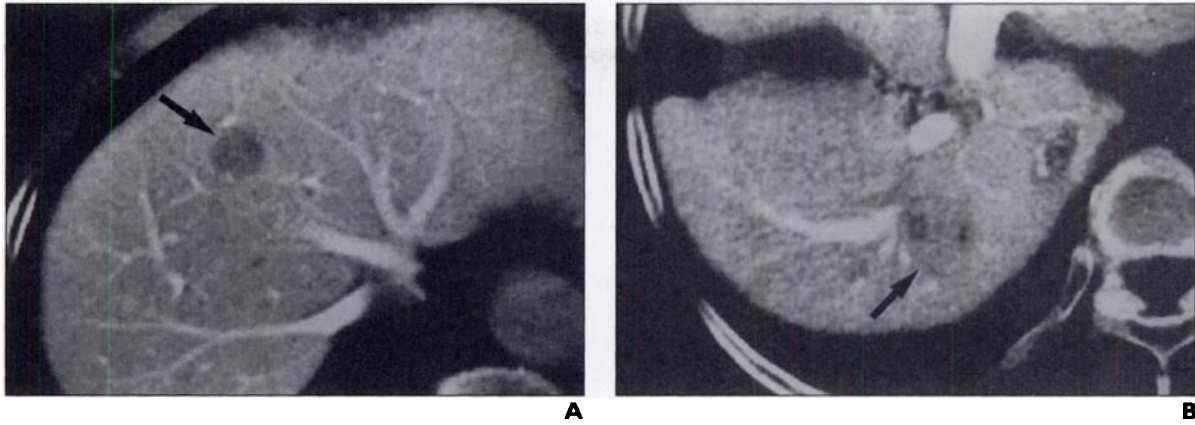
Types of findings on CT during arterial portography.
